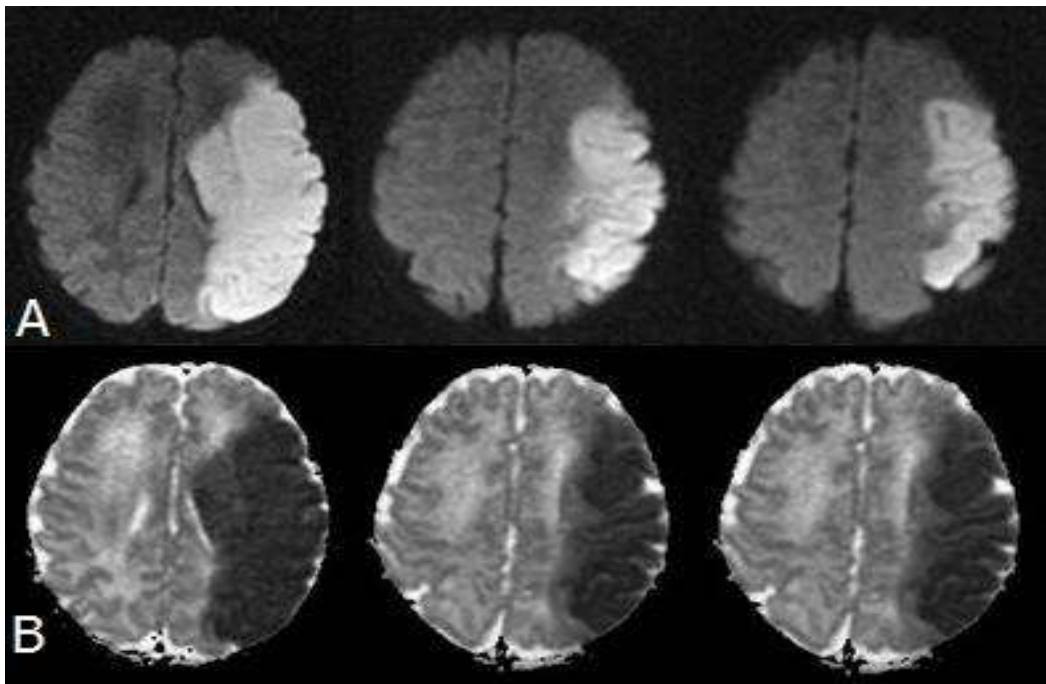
A term infant with complete acute left middle cerebral artery territory ischemic stroke who presented few hours after birth with apneas and right hemibody focal seizures. A and B) Axial diffusion weighted MRI brain demonstrating diffusion restriction in the left frontal and parietal lobe regions and basal ganglia with corresponding apparent diffusion coefficient map consistent with an acute ischemic infarction involving the left middle cerebral artery territory.
